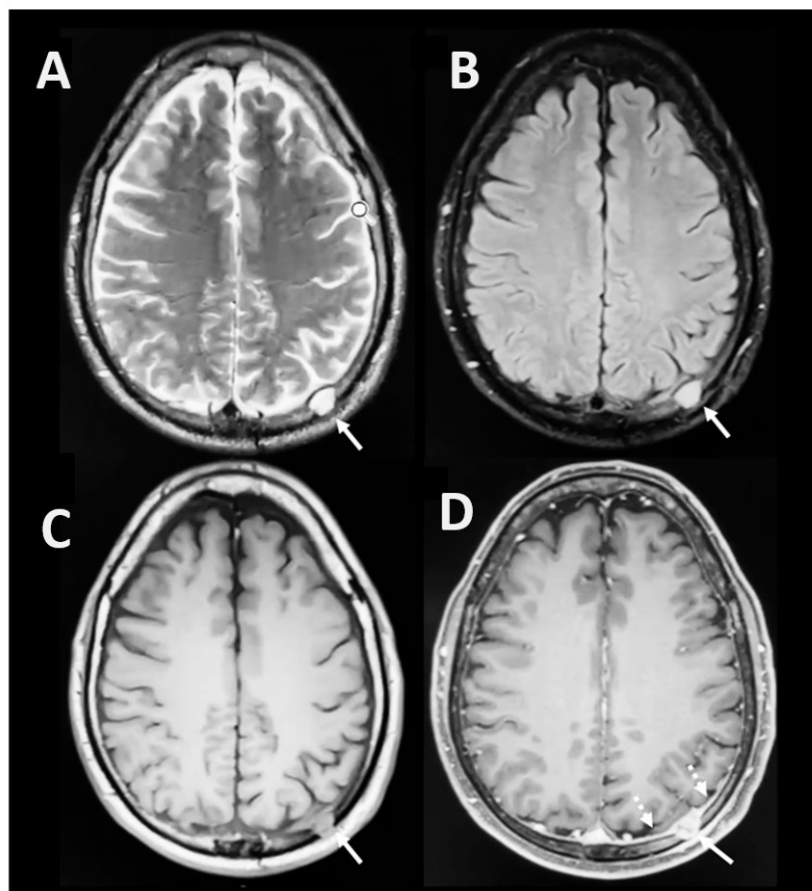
Magnetic Resonance Imaging. Lytic lesion (arrows) at the left parietal level with a high signal in T2 (A) and in FLAIR (B), in T1 (C) isointense with intense enhancement in post-contrast T1 (D). In the post-contrast sequence, dural thickening is evidenced below the lesion with a sign of the “dural tail” (D-dotted arrows).
